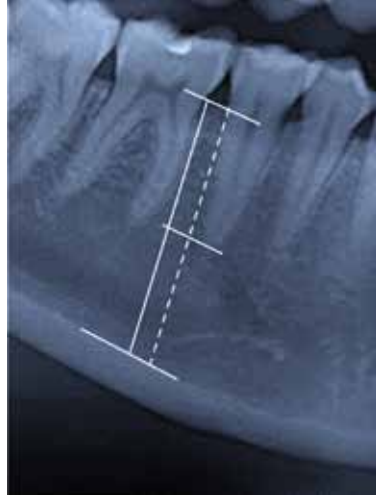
The method of quantitative determination of the degree of bone tissue destruction of the alveolar part relative to the root length (X-ray index)
